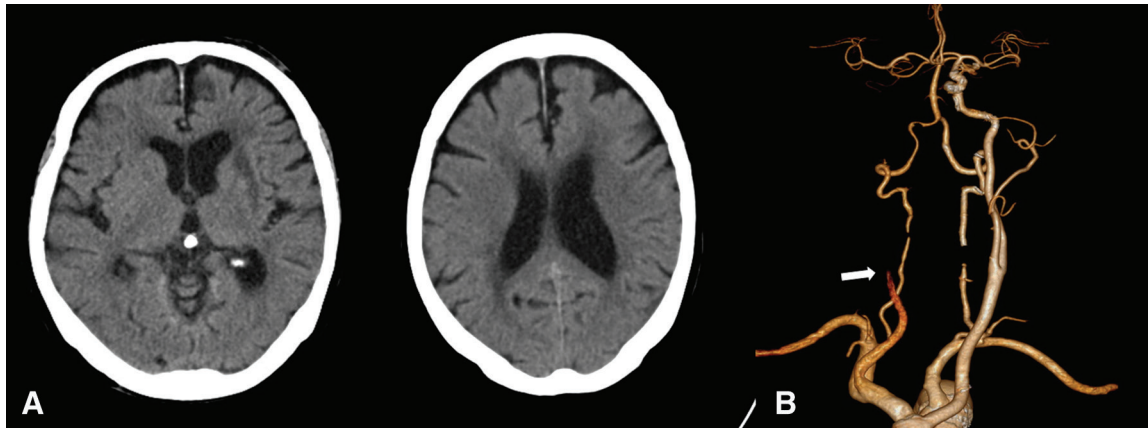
Imaging on arrival. (A) Axial section on plain CT. There was no early ischemic change. (B) Rearranged 3D image on CTA. There was a contrast defect involving the right CCA (white arrow) to ICA and ECA. The right MCA was visualized via the A-com. A-com: anterior communicating artery; CCA: common carotid artery; ECA: external carotid artery; ICA: internal carotid artery; MCA: middle cerebral artery
